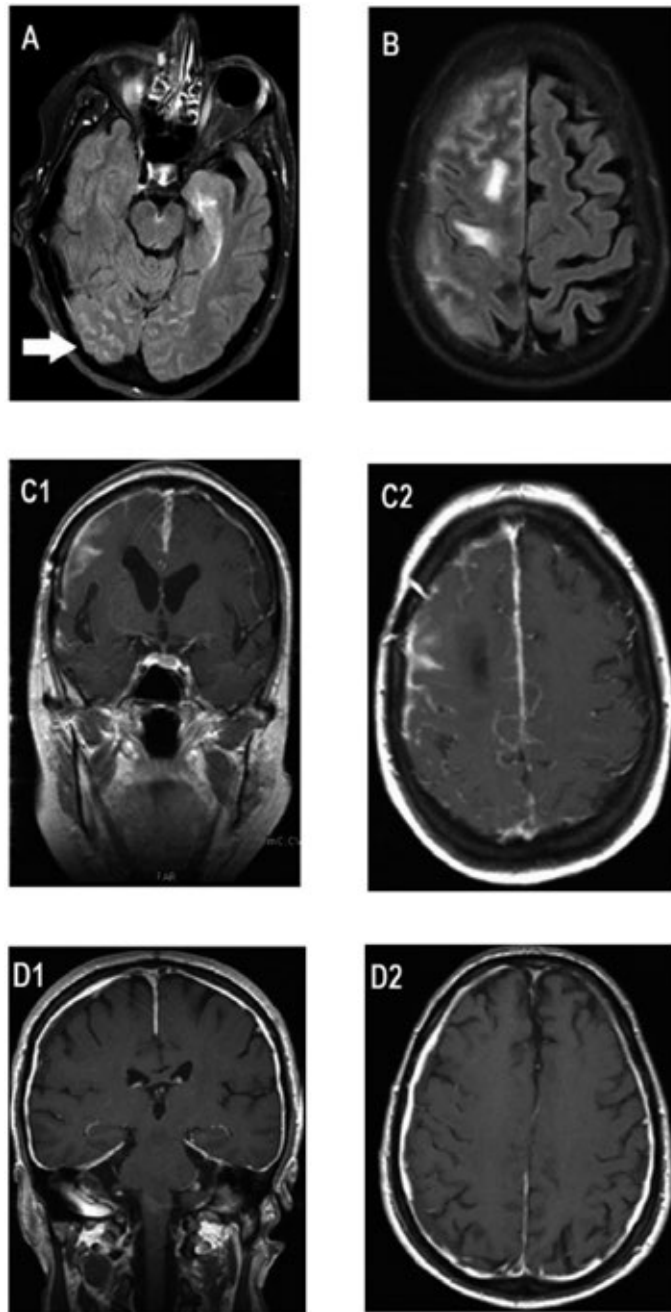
Magnetic resonance imaging (MRI) of the brain from individuals with pachymeningitis. (A) pachymeningitis with leptomeningeal enhancement overlying the occipital lobe (arrow) in a patient with RA presenting with optic neuritis; (B) Unilateral dural and leptomeningeal thickening and enhancement over superior R frontal lobe convexity and sulci extending into interhemispheric fissure in R medial frontal lobe in a patient with blastomycosis who developed focal seizure and L sided numbness who ultimately developed RA one year later; (C1, C2) Coronal and transverse plane images (respectively) demonstrating R cerebral dural, leptomeningeal enhancement seen in patient with RA presenting with acute confusion and L hemiparesis, L sided sensory loss, and L hemineglect; (D1, D2) Coronal and transverse plane images (respectively) demonstrating diffuse bilateral meningeal enhancement after gadolinium in a patient with RA presenting with R unilateral hearing loss, scleritis, and synovitis.
